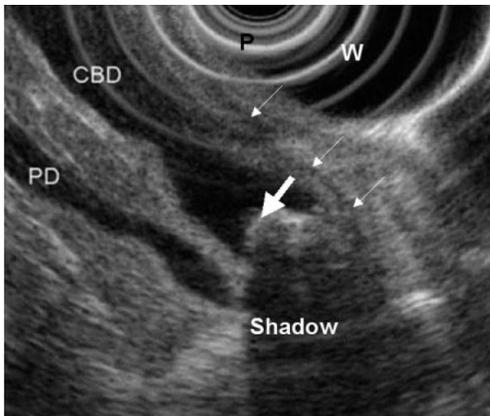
A radial endoscopic ultrasound image showing part of a “stack sign” imaged through the duodenal bulb (common bile duct (CBD) pancreatic duct (PD) and portal vein (not shown) in long-axis view, seen as dark (hypoechoic) stripes parallel to one another). A wedge shaped dark (hypoechoic) acoustic shadow is seen behind the bright (hyperechoic) 4-5 mm stone (arrow), making even this small stone appear quite obvious. P=probe at tip of scope; W= water filled balloon around probe. Small arrows indicate tangential view of duodenal wall.
